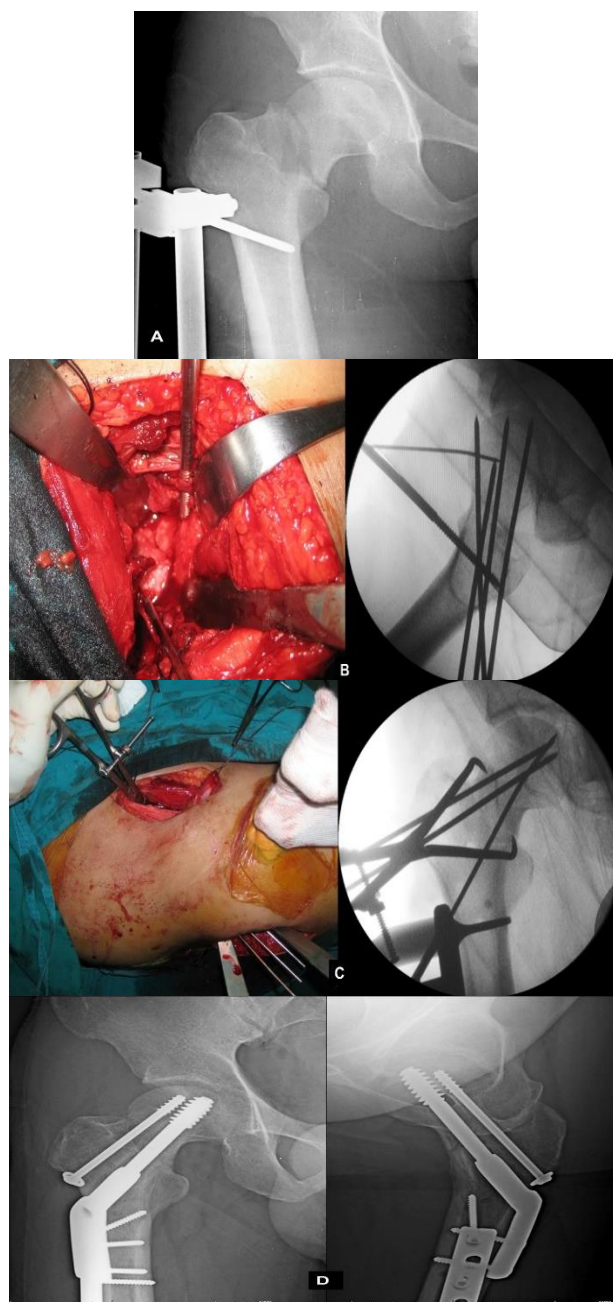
Radiograph of a vertical femoral neck fracture Pauwels type 3 (A), open reduction internal fixation by application of the joystick and Weber clamp using the modified Smith-Petersen approach (B), temporary pins fixation from a separate lateral incision (C), anteroposterior (AP) and lateral radiographs of the final fixation with sliding hip screw and anti-rotation screw (D)
